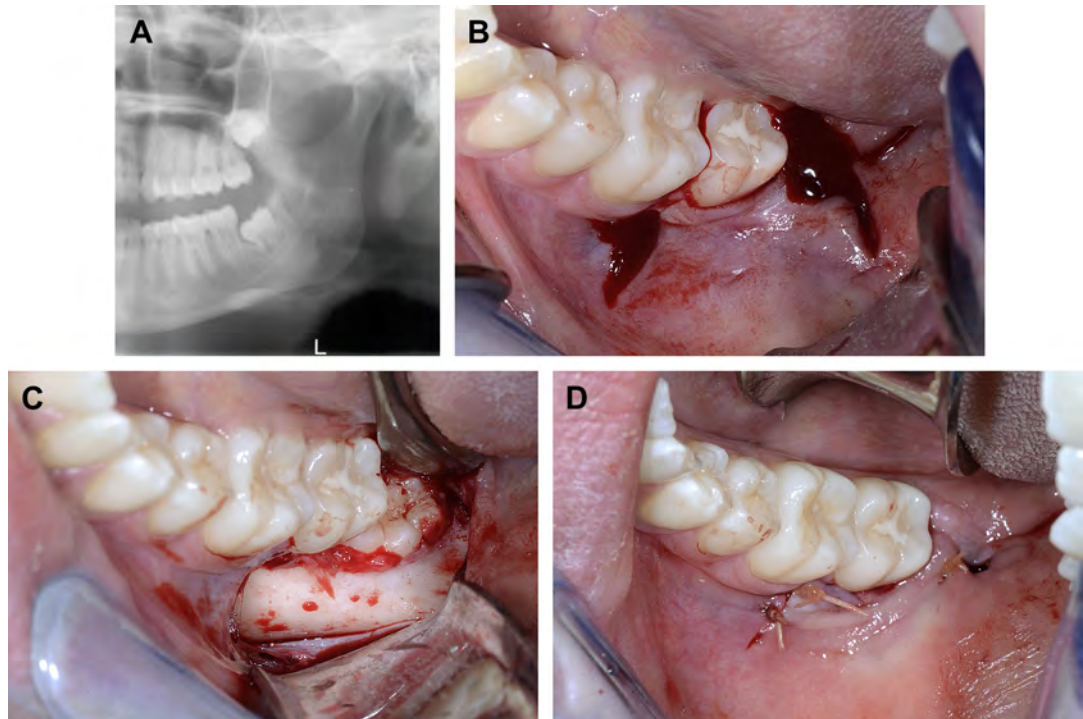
(A) Radiograph of impacted mandibular left third molar. (B) Three-cornered flap with anterior vertical release and posterior divergent lateral incisions. (C) Three-cornered flap, soft tissue reflected laterally. (D) Three-cornered flap sutured.
